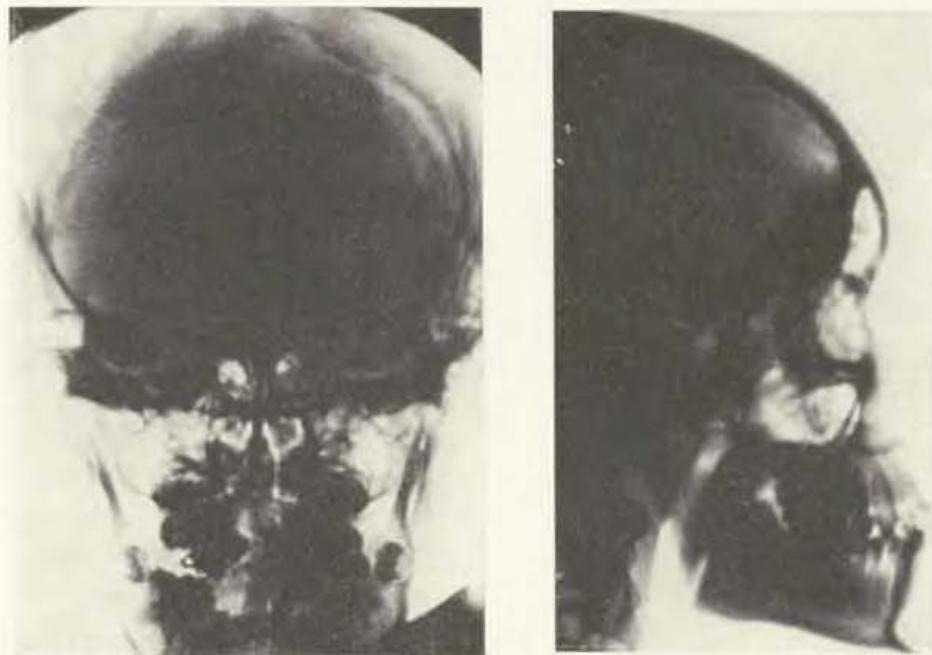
X-rays J.Q. to show maxillae after excision of vomer.
